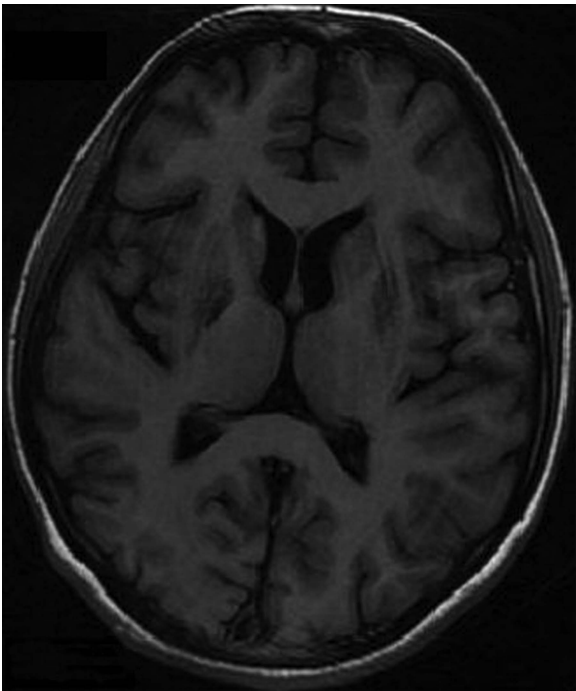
Follow-up (after 4 weeks) MRI with T1-weighted sequence showing a significant resolution of basal ganglia lesion.
